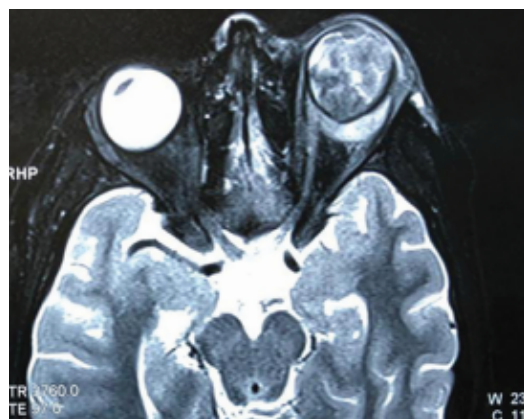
Magnetic resonance imaging of the orbit showing vitreous echoes with retroscleral thickening with proptosis of left eye
